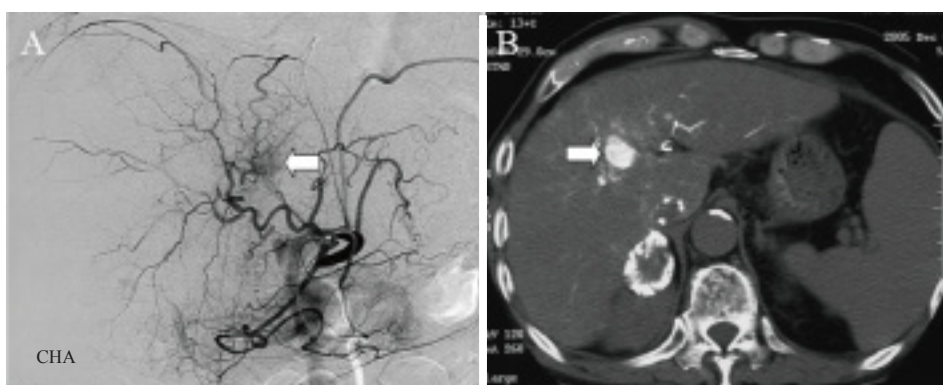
A: A faint tumor (arrow) seen in segment 4 of the liver on a common hepatic arteriogram; B: A contrast-enhanced lesion (arrow) observed in segment 4 of the liver on computed tomography during a hepatic arteriogram.
